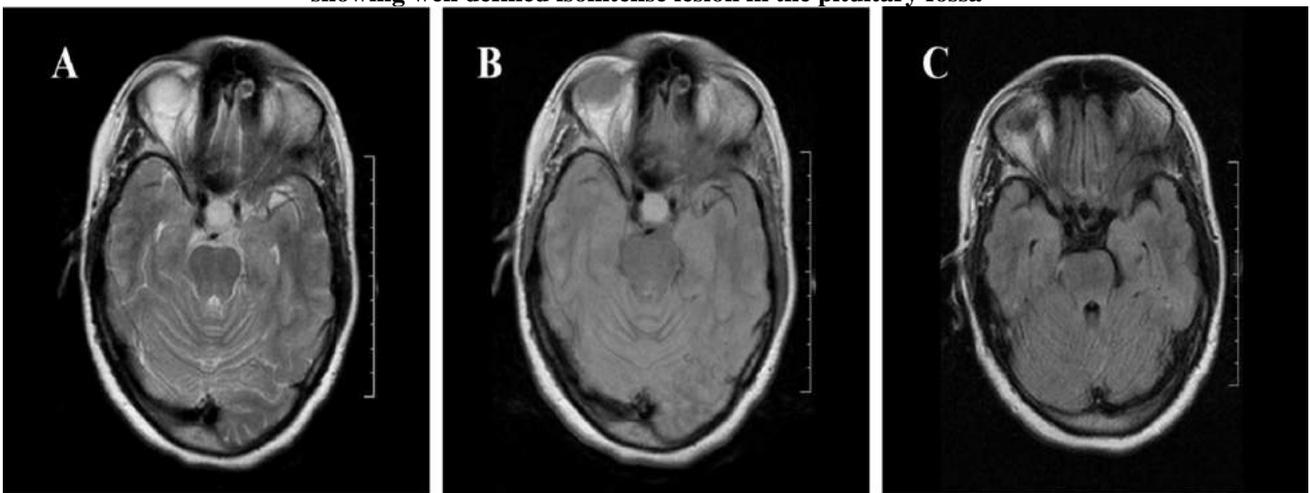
MRI BRAIN - Images: A - T2 Axial View and B - FLAIR - Axial View showing well defined hyperintense lesion in the pituitary fossa and C - Post Operative FLARE - Axial View showing complete excision of the lesion on follow up scan
